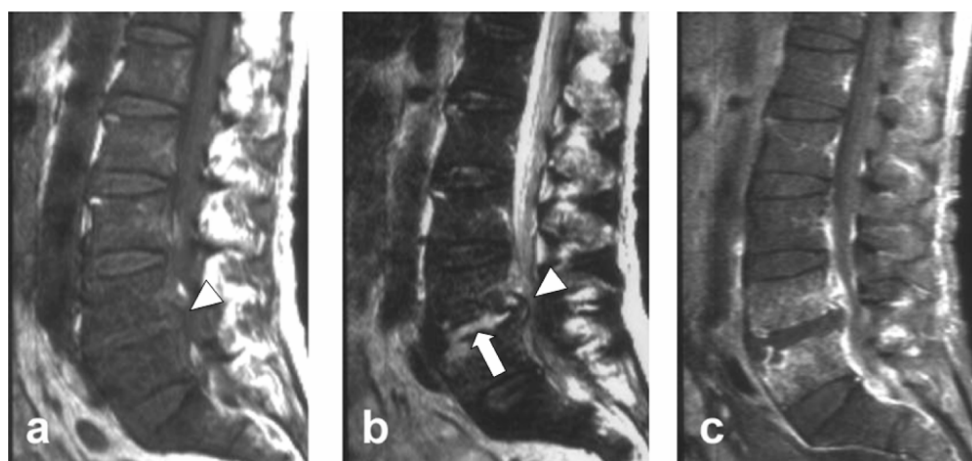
Bacterial spondylitis of L4-5 (a, b, c) Magnetic resonance image of the lumbar spine in a 64-year-old man presented with back pain and leg weakness, (a) pre-Gadolinium T1-weighted in sagittal plane (b) T2-weighted in sagittal plane (c) Post-Gadolinium T1-weighted in sagittal plane show classical findings of spondylitis with involvement of intervening disc which can not be differentiated from tuberculous spondylitis (white arrow), linear dark line of the posterior longitudinal ligament on both T1-weighted and T2-weighted images is not well demonstrated and possible destroy by bacterial proteolytic enzyme (arrow heads)
